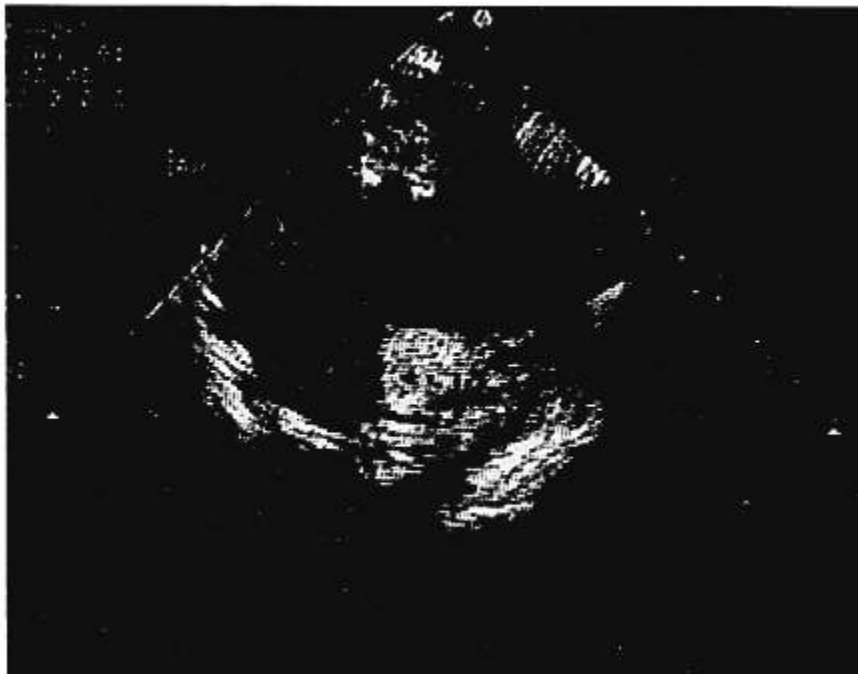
Two-dimensional transesophageal echocardiographic display of the left ventricular short-axis view at the midpapillary muscle level after placement of the pulmonary artery vent. Pulmonary artery pressure (PAP) is -6 mmHg; mean arterial pressure is 44 mmHg. Despite the low PAP, severe distention is apparent.
